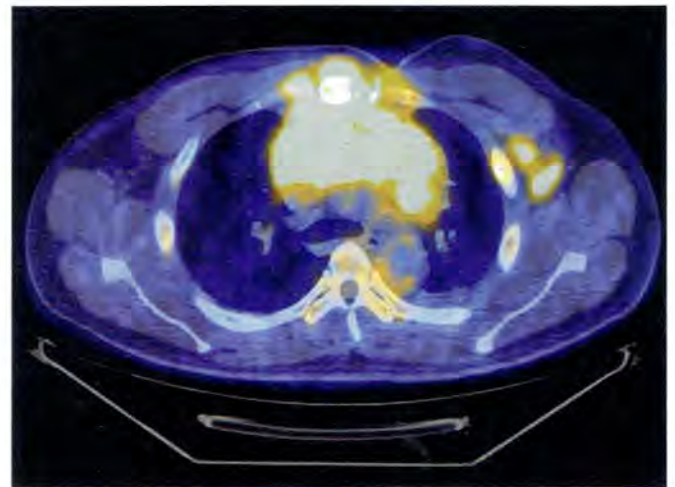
Intense radiotracer accumulation is observed at this location on positron emission tomography/computed tomography (PET/CT) images, confirming lymphomatous involvement of bone marrow.
